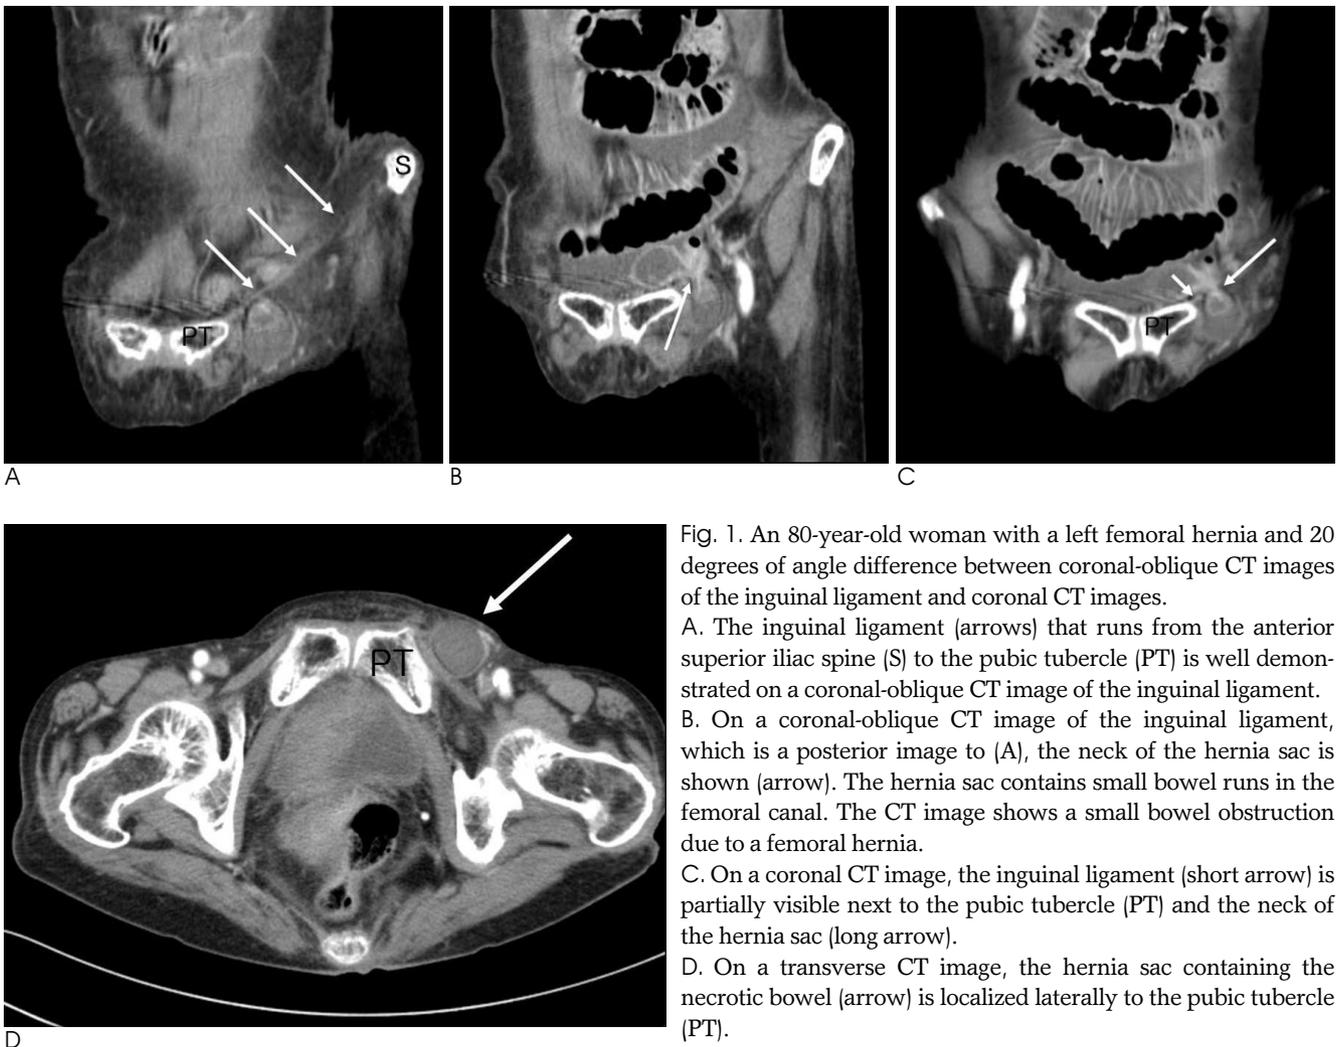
An 80-year-old woman with a left femoral hernia and 20 degrees of angle difference between coronal-oblique CT images of the inguinal ligament and coronal CT images.
